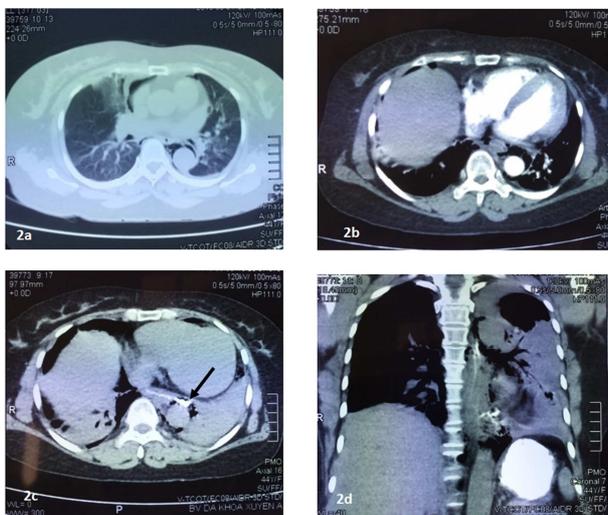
Computed tomography scan showing mediastinitis with free gas bubbles and localized fluid in the posterior mediastinum (2 a, 2 b, 2 c, 2 d), localized fluid in the left pleural cavity (2 d) and an esophago-pleural fistula (2 c, black arrow).
